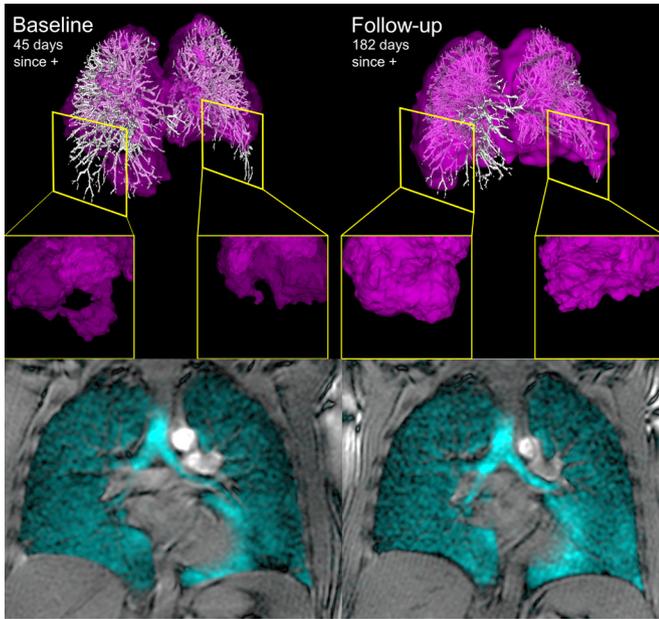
^{129}Xe MRI and coregistered pulmonary vascular tree CT at baseline and follow-up. Left and right panels show ^{129}Xe MRI RBC map (pink) coregistered with CT pulmonary vascular tree (white) and bottom panels show ^{129}Xe ventilation images (cyan) for a previously healthy participant hospitalised with COVID-19 symptoms and pulmonary embolism. At baseline, 45 days post-COVID-19 positive test, RBC:TP ratio was abnormally low (0.37) and insets provide examples of RBC map defects. At follow-up the RBC:TP ratio improved (0.54) as did the lower lobe red blood cell map defects shown in the right panel inset. DL_{CO} (baseline=93%pred, follow-up=110%pred) and total SGRQ score. (baseline=23, follow-up=5) also improved at follow-up. DL_{CO} , diffusing capacity of the lung for carbon monoxide; RBC, red blood cell; SGRQ, St George's Respiratory Questionnaire.
